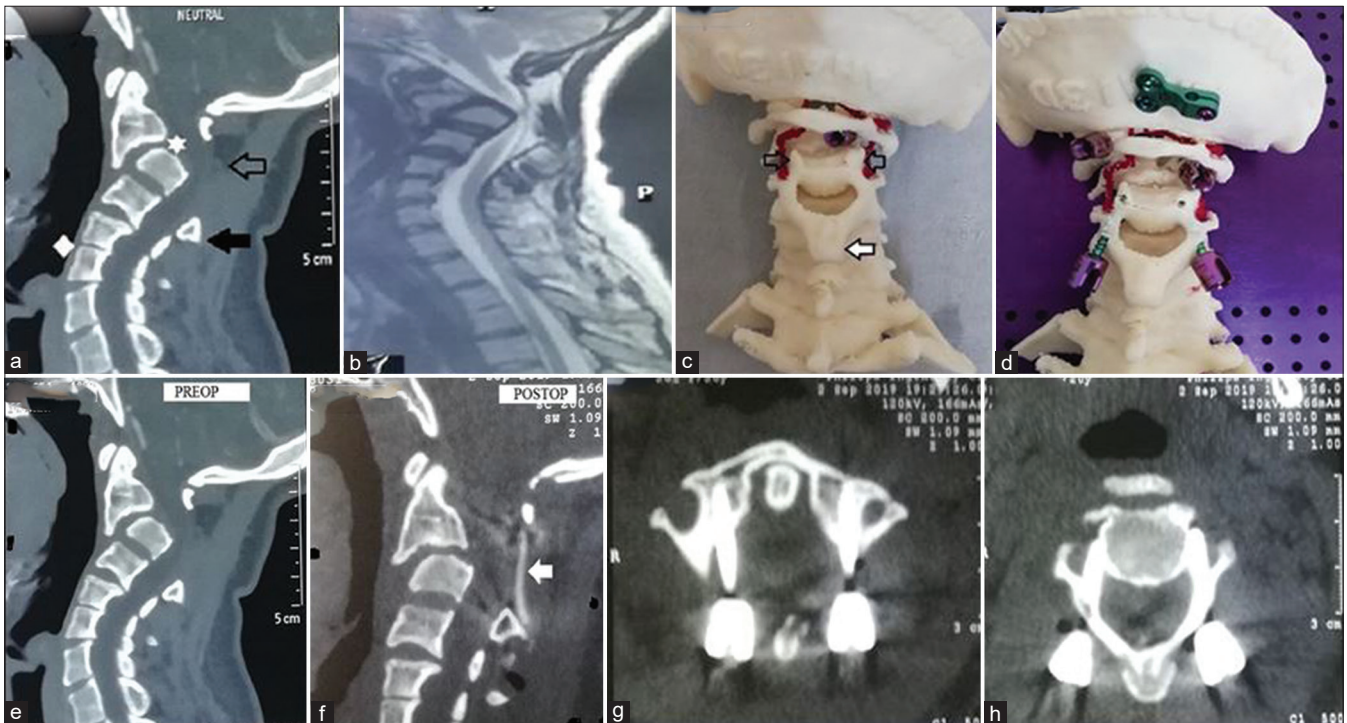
Uncommon case of absent C2 posterior elements with C2–C3 spondyloptosis; (a) preoperative computed tomography (CT) scan (MidSagittal cut) showing absent C2 lamina (hollow arrow), C2–C3 spondyloptosis (asterix), hypertrophied spinous process of C3 (solid arrow), and C5–C6 block vertebra (diamond), (b) magnetic resonance imaging T2W image, midsagittal section showing severe cord compression by retropulsed C3 body, (c) 3D model of the craniovertebral junction of the patient showing posterior view with absent C2 lamina, well developed uncinat process of C3 (hollow arrow), and hypertrophied spinous process of C3 (solid arrow), (d) showing hands on practise on the model preoperatively, (e and f) comparison between the preoperative and postoperative CT scan (Mid Saggital view) of the patient showing acceptable reduction and realignment of the C2–C3 body with increased canal diameter at the level of C3 and iliac bone graft between C1 posterior arch and C3 spinous process *in situ* (solid arrow). The model helped us in better understanding of the complex anatomy and planning preoperatively, and (g and h) C1 lateral mass and C2 pedicle screw insertion.
